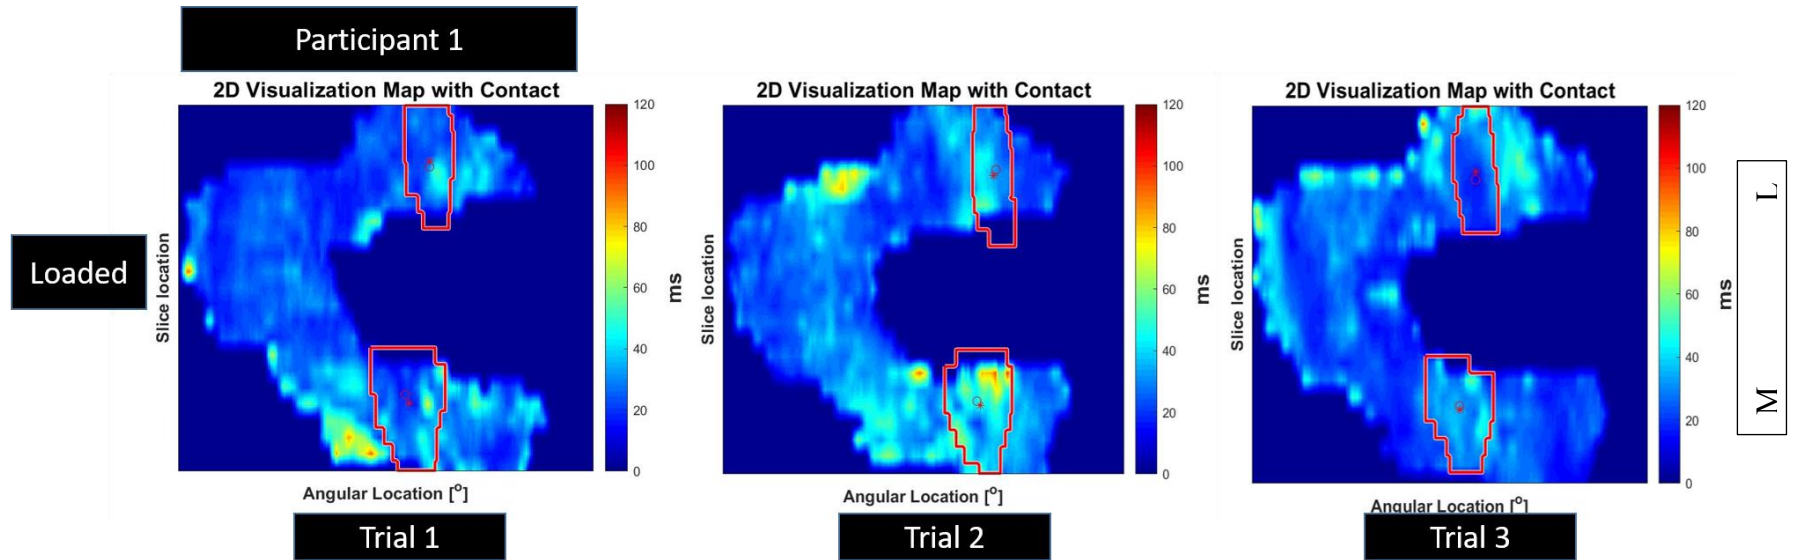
Figure B-2-1: T₂ Projection Maps of Loaded cartilage for Three Trials of Participant 1. The T₂ Projection maps of the unloaded cartilage is not available for this participant due to MRI sequence error.
